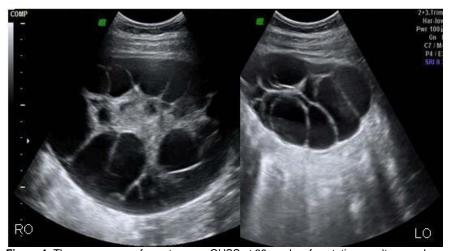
The appearance of spontaneous OHSS at 39 weeks of gestation on ultrasound.
